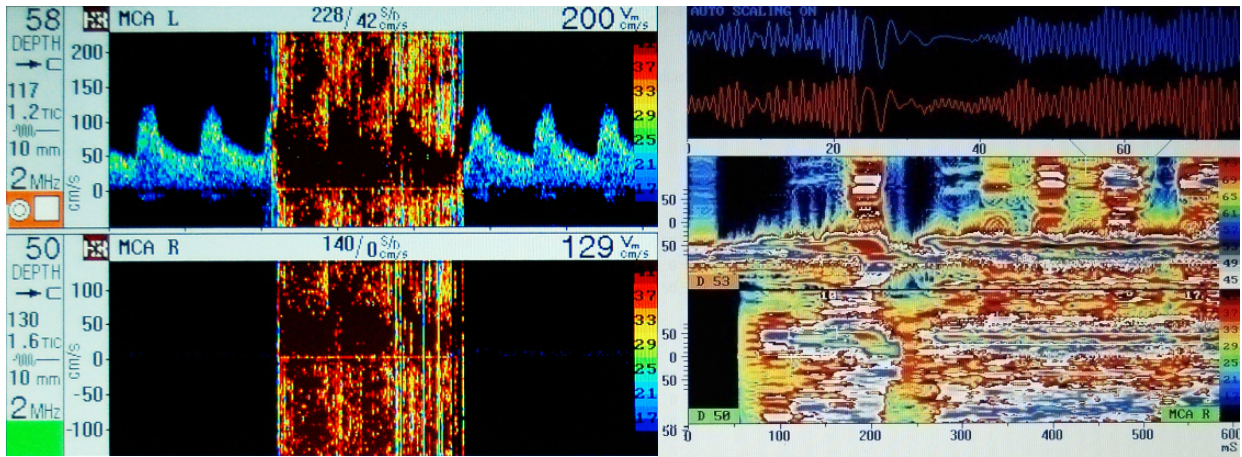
HITS “shower” detected during contrast media injection. Individual emboli could not be identified. Left: Doppler waves and the artifact caused by gas bubbles. Right: fast Fourier transformation of the data on the left.
